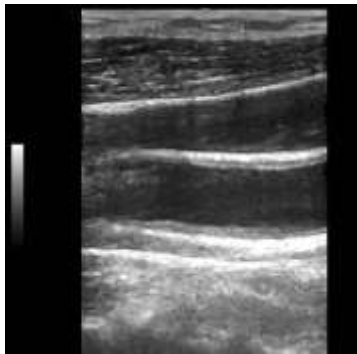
ultrasound image of the common carotid artery showing thickened intima media
